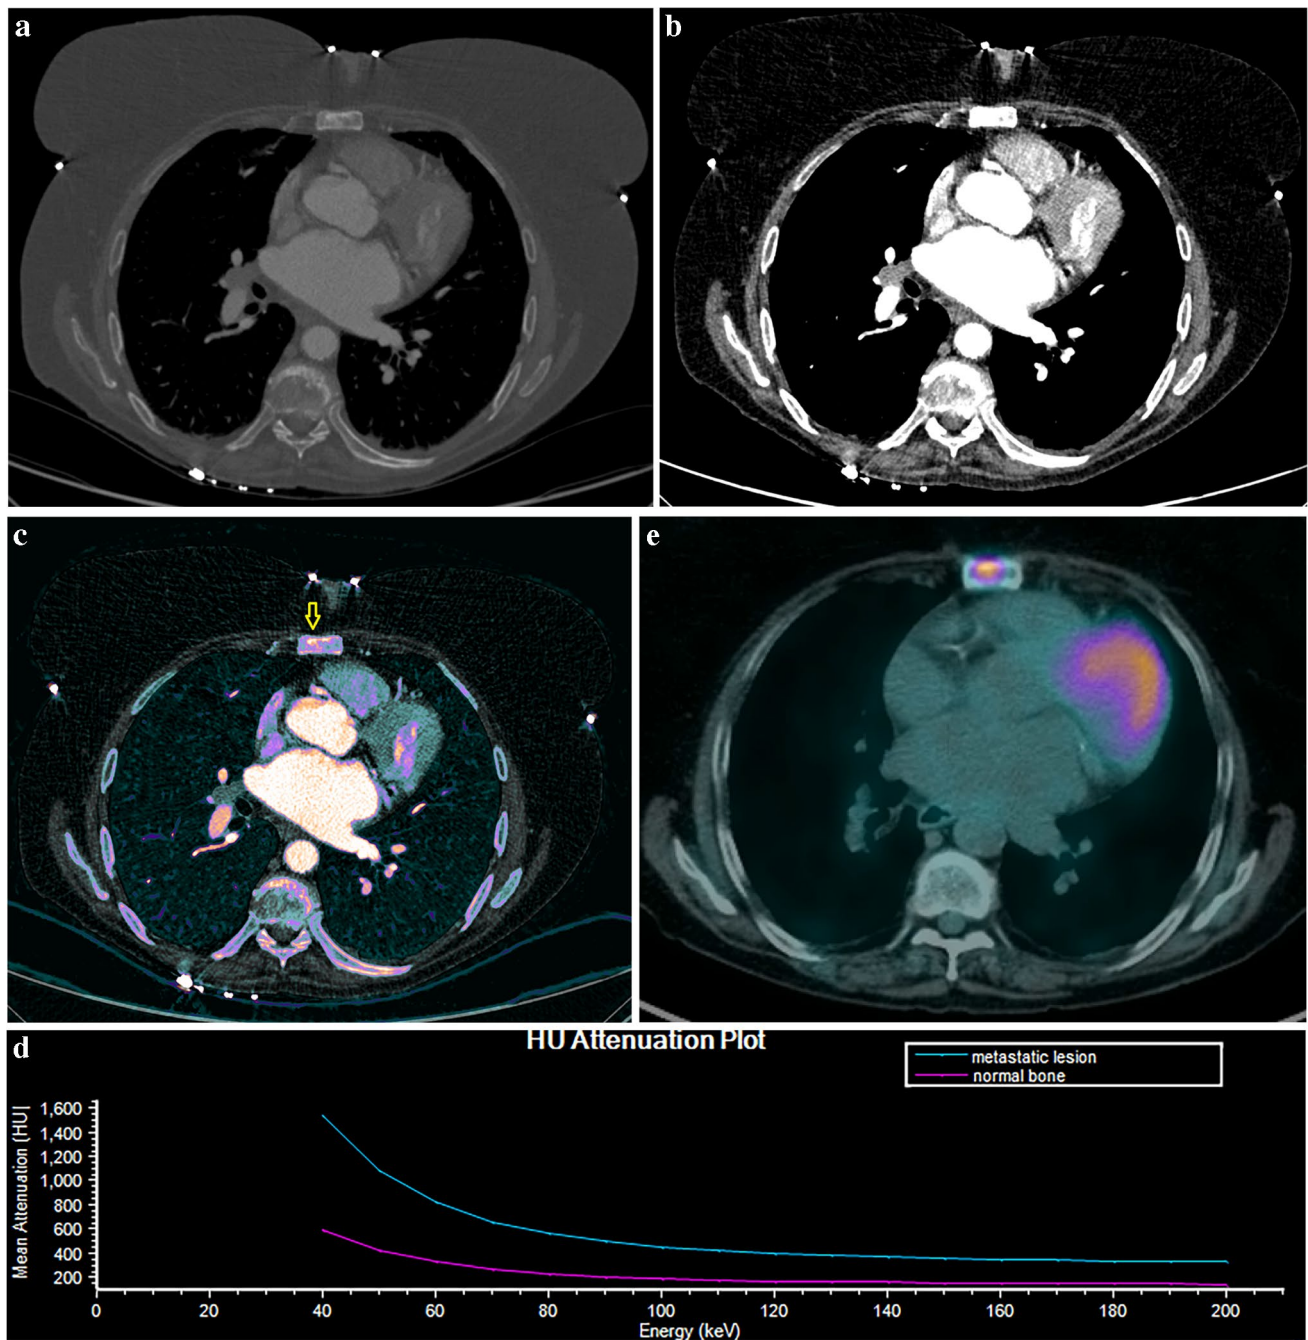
Axial contrast-enhanced CT scan of a woman in her 60 s with small cell lung cancer metastasis to the sternum. a Equivocal findings for a metastatic in the sternum on virtual monoenergetic CT at 70 keV. b Image in soft tissue window. c Iodine-no-water maps
